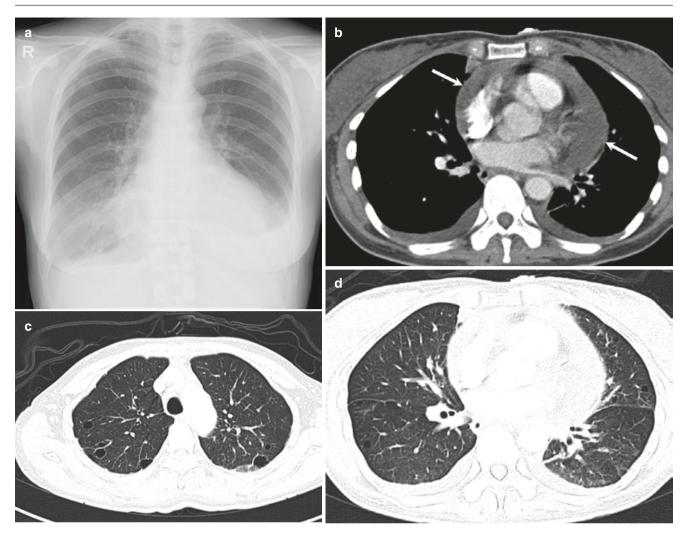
A 58-year-old woman with mixed connective tissue disorder and LIP. (a) Frontal chest radiograph shows bilateral pleural effusions. (b) Axial CT image in soft tissue window shows bilateral pleural effusions and a pericardial effusion (white arrows). (c, d) Axial CT images
